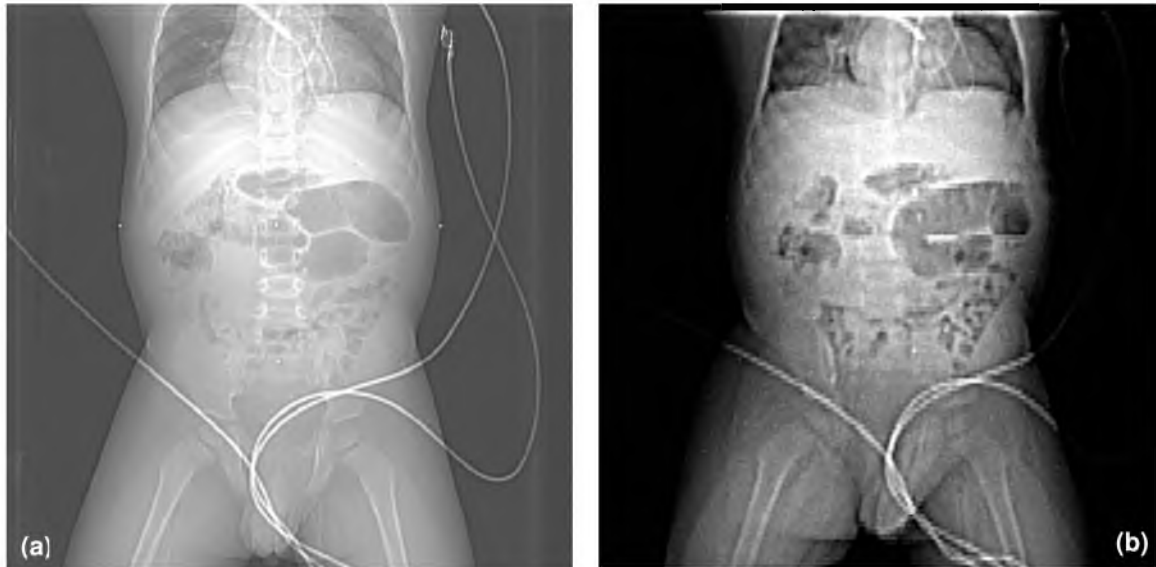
(a) Actual kV X-ray scout, and (b) 230 MeV proton radiograph of a 3 $\frac{1}{2}$ year old pediatric patient.
